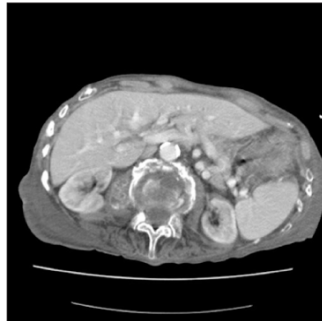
Second CT scan of abdomen showing the reduction in abscess size.
